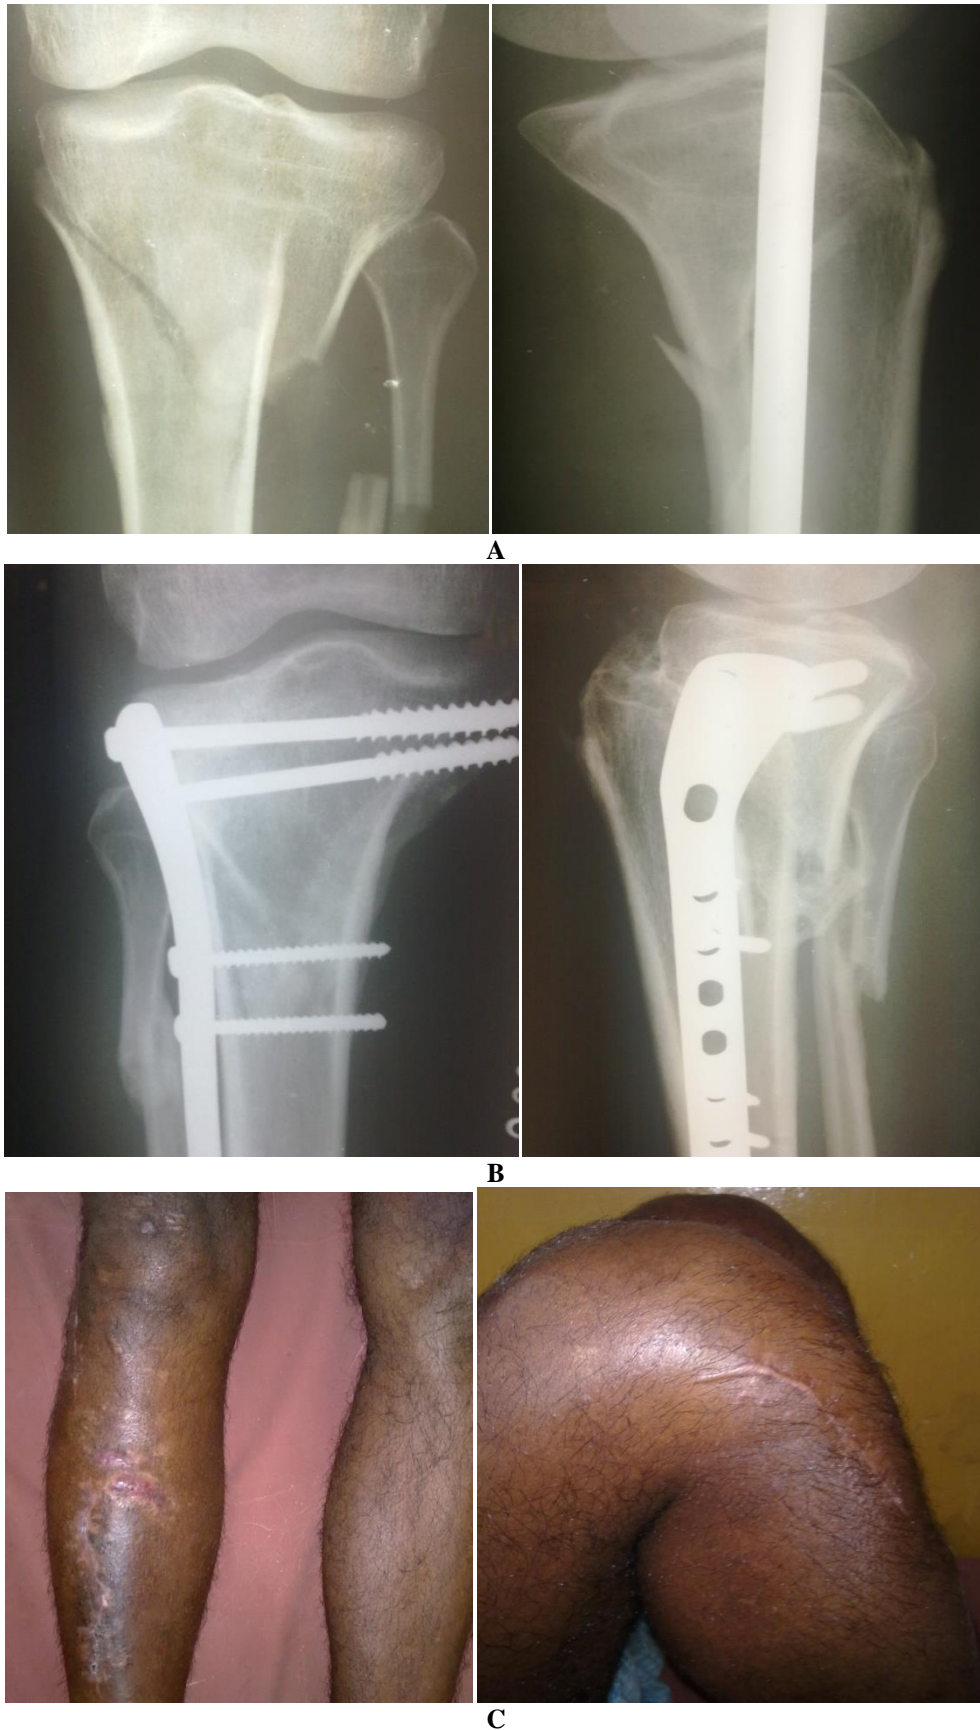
A). Preoperative anteroposterior and lateral radiograph of 37 year old male patient. B). post operative radiographs at 6 months showing fracture union. C).Clinical photographs of the same patient at 6 months showing full knee flexion on the operated limb treated with plating
